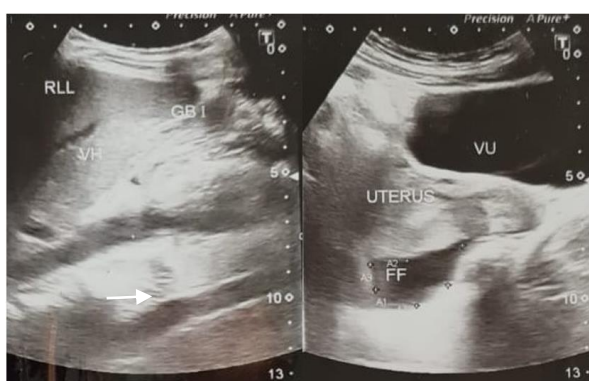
Abdominal ultrasound indicated a collapsed gallbladder and free fluid in the pelvic cavity. (RLL : Right Liver Lobe; VU: Vesica Urinary; GB: Gallbladder; FF: Free Fluid)
